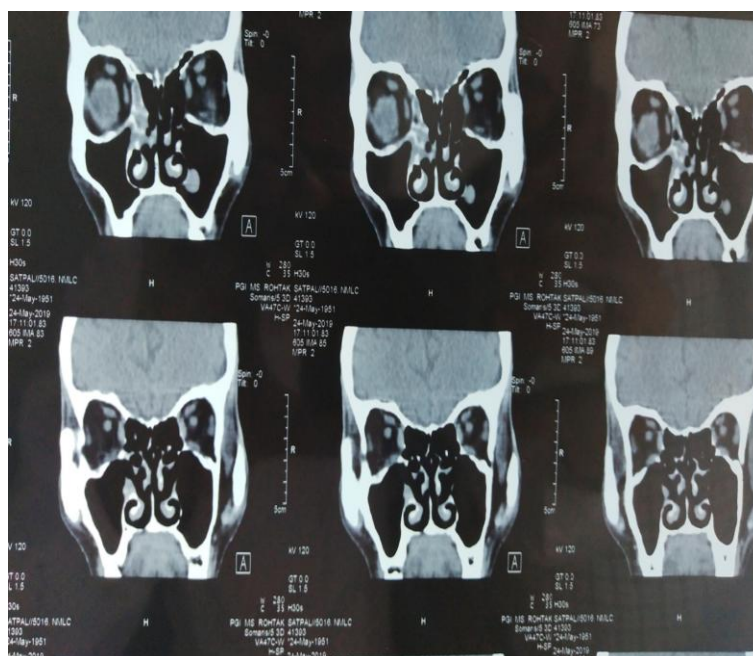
CT PNS-right frontal and left maxillary mucosal thickening suggestive sinusitis
